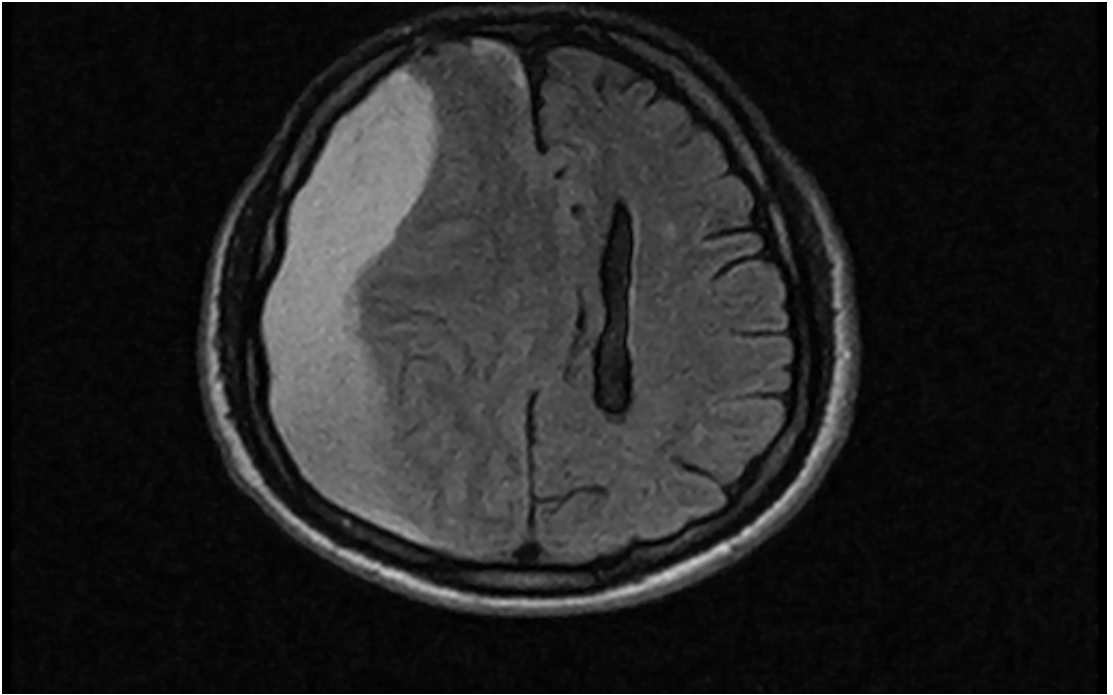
Subdural hematoma on MRI
